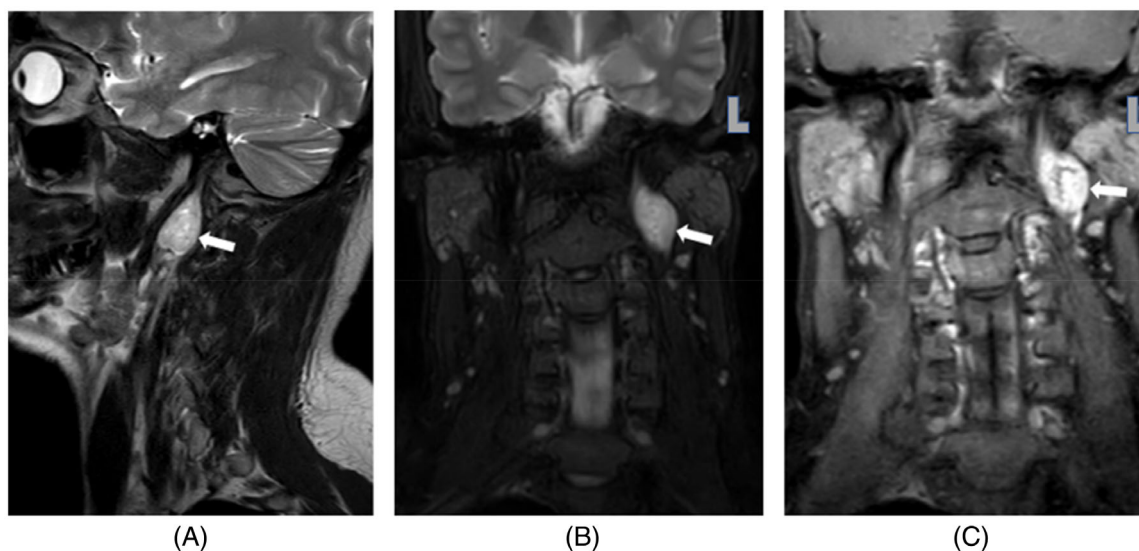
MRI findings. (A) Sagittal T2-WI showed a mass with heterogeneous signal hyperintensity (arrow). (B) Coronal T2-WI (arrow). (C) Contrast-enhanced T1-WI showed a mass with heterogeneous enhancement on coronal section (arrow) [Color figure can be viewed at wileyonlinelibrary.com]
